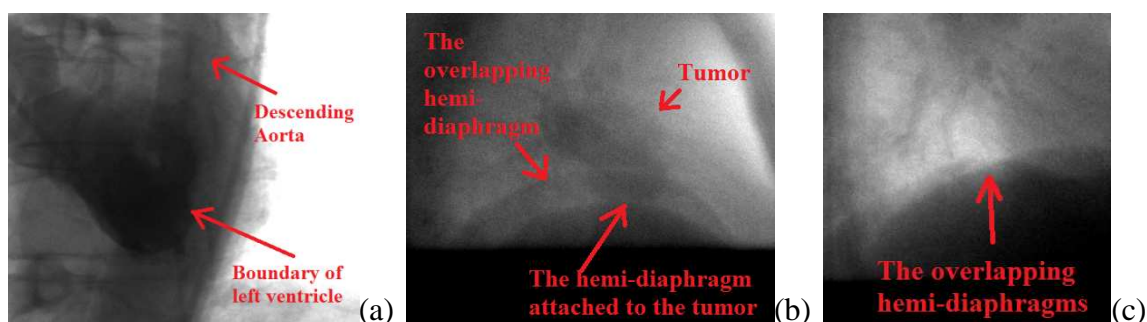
Examples of some cone beam projection images which have significant overlapping organs: (a) C-arm angiography of left ventricular area. The left ventricle is overlapped with descending aorta; (b) MVCBCT projection images of lung with NSCLC. The tumor and the hemi-diaphragm overlapped with the contra-lateral hemi-diaphragm; (c) The overlapping of the contra-lateral hemi-diaphragms.
